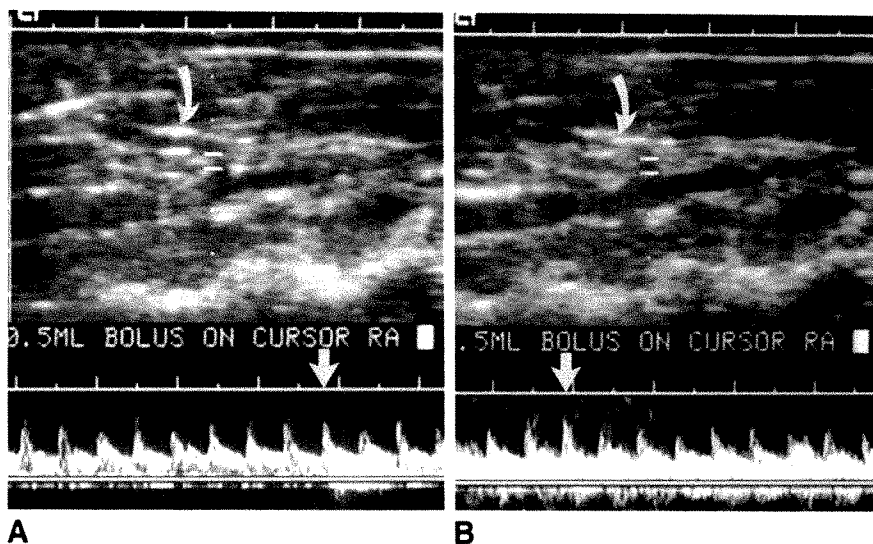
Coronal sonograms of left main renal artery (curved arrow) show effect of 0.5 ml of microspheres on renal arterial Doppler signal.
